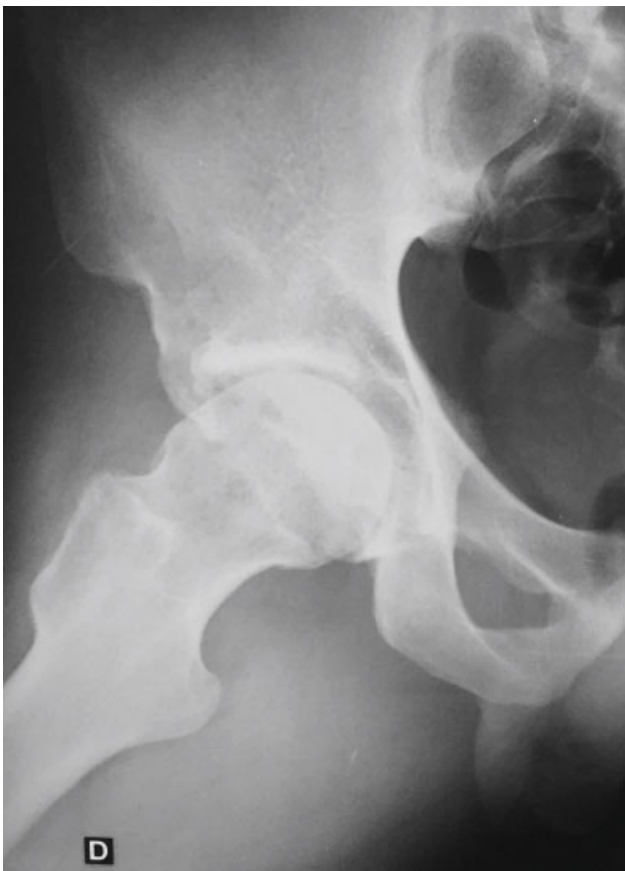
Preoperative radiography in DUNN view 45° evidencing the presence of cam-type deformity. Alpha angle: 80°.
